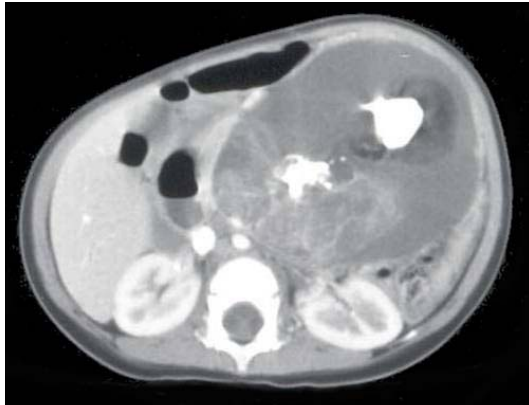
Abdominal CT scan in our patient, showing a 12 x 8 cm, well-demarcated, cystic mass with calcification and solid and fat components in the left upper quadrant of the abdomen.
